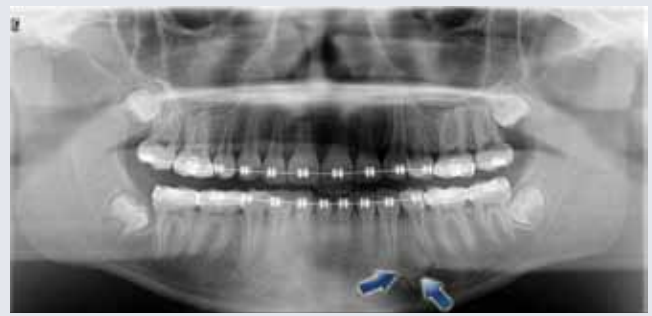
A circumscribed radiolucent lesion in the panoramic radiograph suggests anything from a juvenile to cemento-ossifying fibroma (fibrous dysplasia), to Stafne’s idiopathic bone cavity to a giant-cell granuloma.
